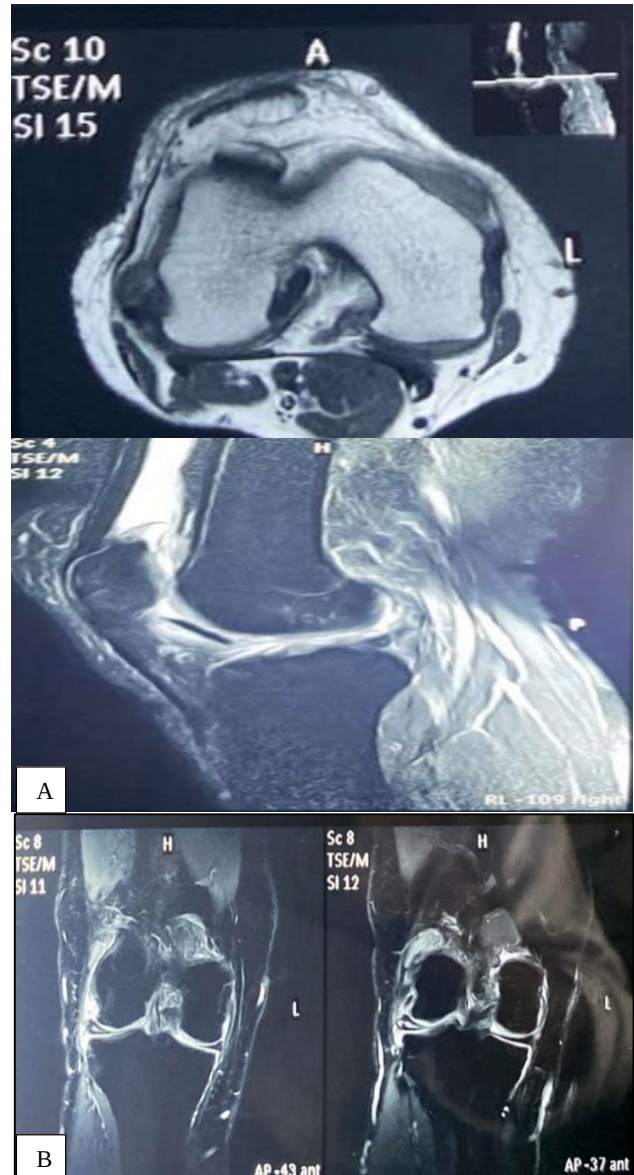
(A and B): Axial and sagittal section of MRI of the right knee showing edema around the foreign body and coronal section of MRI of the right knee showing lateral meniscus tear.
